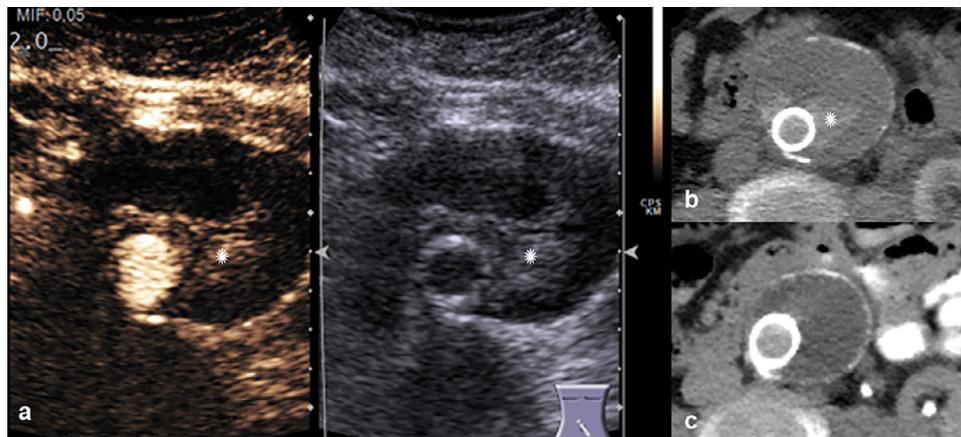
False positive: Inhomogeneous thrombosis. (a) Extensive inhomogeneous hyperechoic structure (*asterisk*) inside the aneurysm sac surrounding the aortic tube graft (Aorfix Extender, Lombard Medical Limited, Didcot Oxfordshire, UK). The structure is identically seen in B-mode sonography before and after intravenous contrast agent injection. (b) Verification of inhomogeneous hyperdense thrombus material (*asterisk*) surrounding the stent graft in computed tomography. (c) Follow-up computed tomography after 6 mo reveals a regressive thrombus and aneurysm sac shrinkage.
